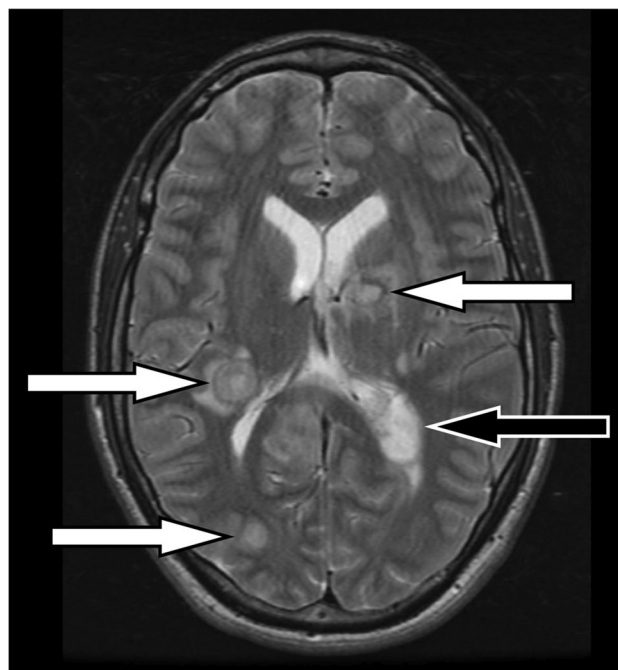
17-year-old boy with brain abscesses due to disseminated histoplasmosis. Axial T2-weighted MR image of the brain shows multiple intraparenchymal abscesses (white arrows) as well as enlargement of the left lateral ventricle choroid plexus consistent with choroid plexitis (black arrow)
